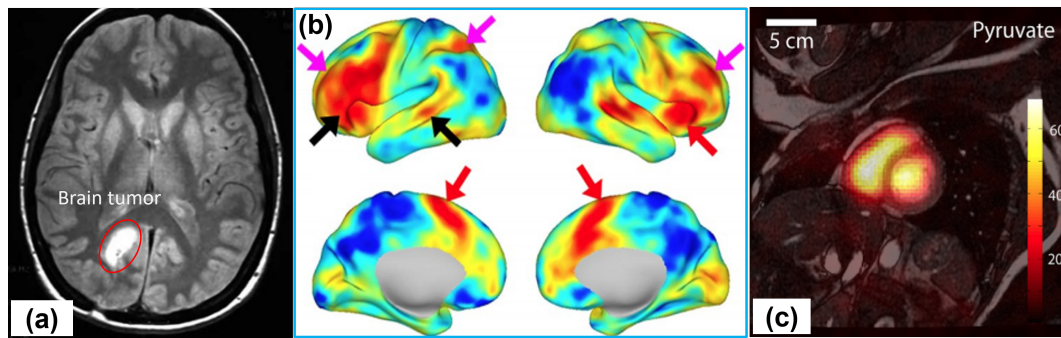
(a) MR anatomical image showing the brain tumor. Image source: [1]. (b) Functional MRI response to word generation. Image source: [2]. (c) ^{13}C pyruvate image of the blood pool in cardiac chambers. Image source: [3].
